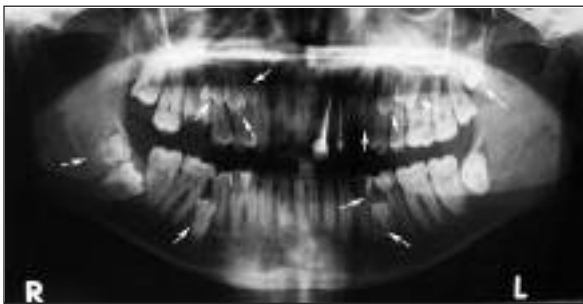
Panoramic radiograph showing the supernumerary teeth (arrows).
